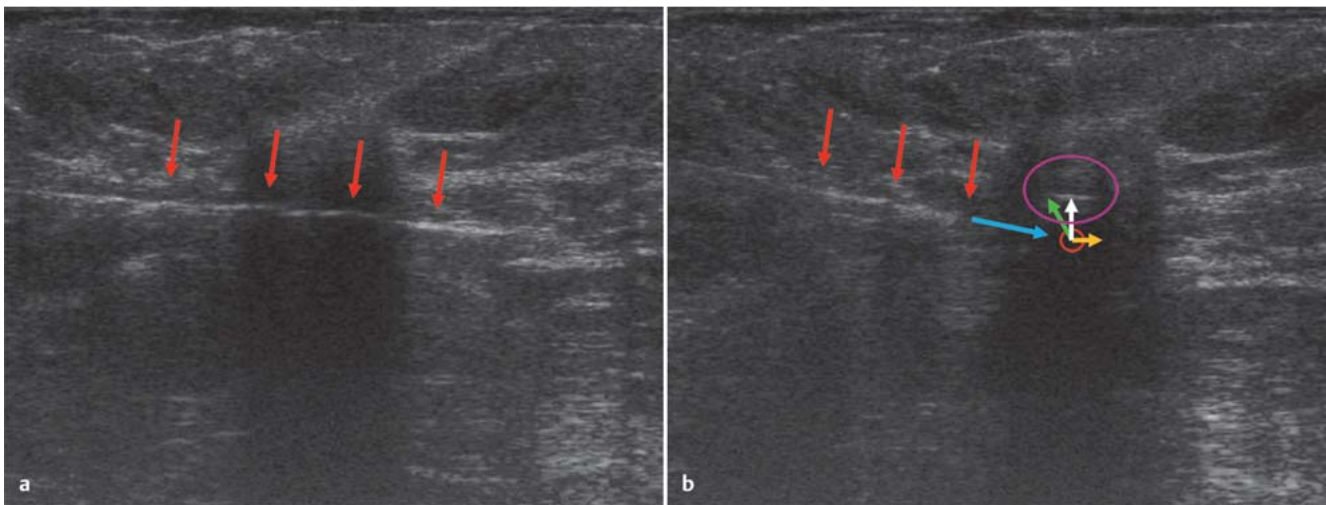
a and b a Ultrasound-guided core needle biopsy of a breast cancer lesion (cT1). The biopsy needle is precisely in the center of the focal tumor (red arrow) (2D, Acuson Antares, 13 MHz (Siemens™), magnification: 3×). b Ultrasound localization of the intramammary marker clip. The biopsy needle tip is sited directly above the focal tumor (red arrows) (2D, Acuson Antares, 13 MHz [Siemens™], magnification: 3×) after placement of the marker
